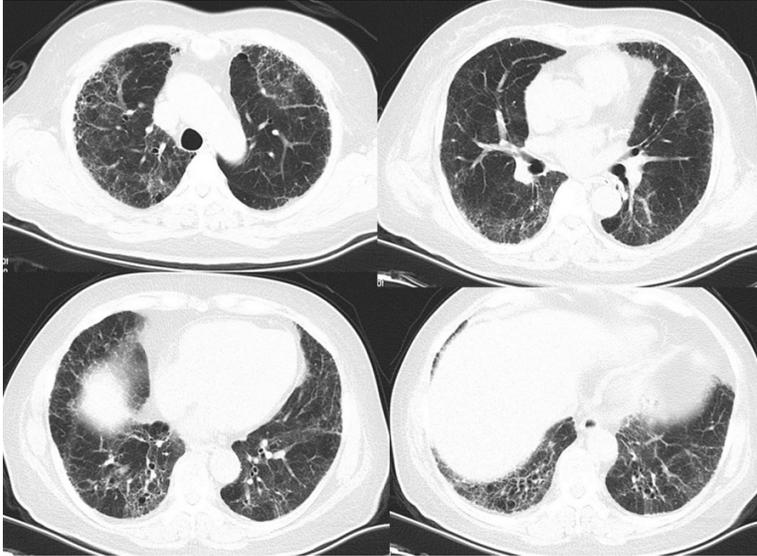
Computed tomography scan of the proband (II.1) before acute exacerbation shows reticulations and subpleural honeycombing in the basal lateral portions of the both lungs.
